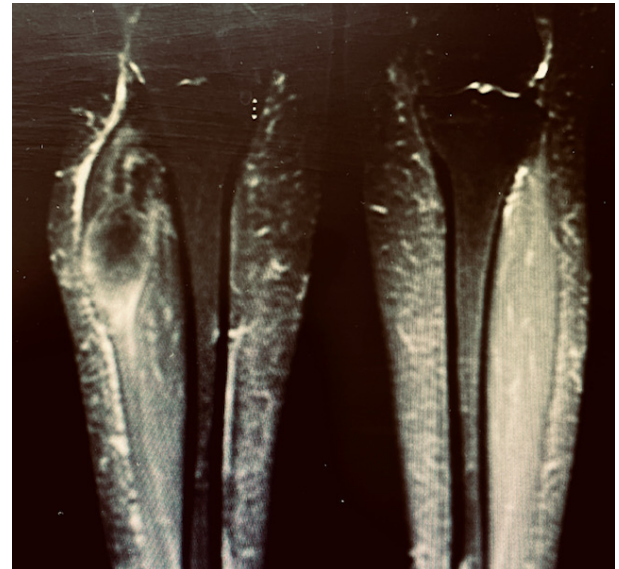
T2-weighted MRI demonstrating a giant cell tumor of the proximal fibula.
